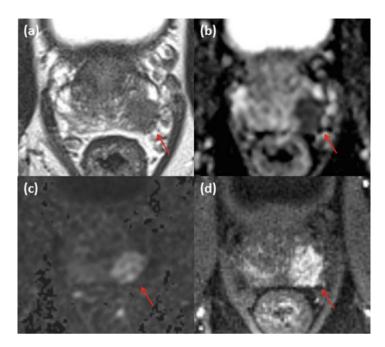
Sixty-six year-old biopsy naïve male with a PSA of 6.2 underwent mpMRI demonstrating a Likert scale suspicion score of 5/5 in the left posterolateral base to mid peripheral zone lesion: T2WI (a), ADC (b), DWI (*b*-value 1500) (c), and DCE (single time-point (d)). Systematic biopsy demonstrated Gleason score 6 (3+3) prostate cancer while MRI-targeted biopsy demonstrated Gleason score 8 (4+4) cancer in 4/4 cores. *Red arrow* points to lesion
